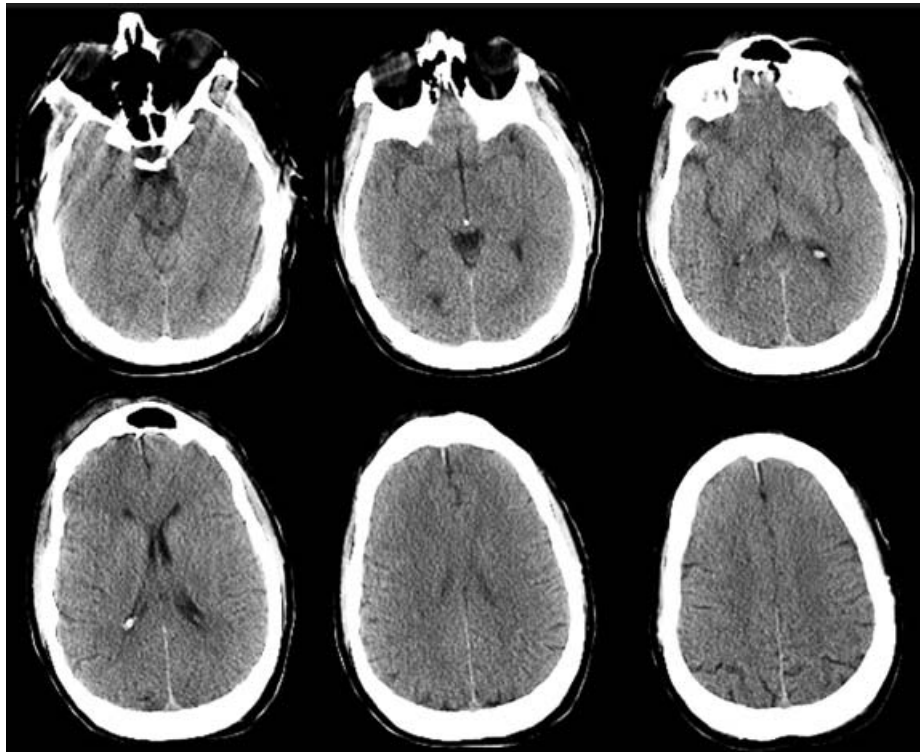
Normal head CT scan.
